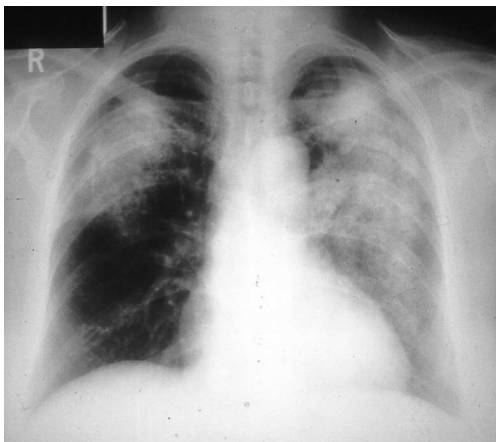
Chest radiograph showing pulmonary haemorrhage in a patient with Wegener's granulomatosis.
